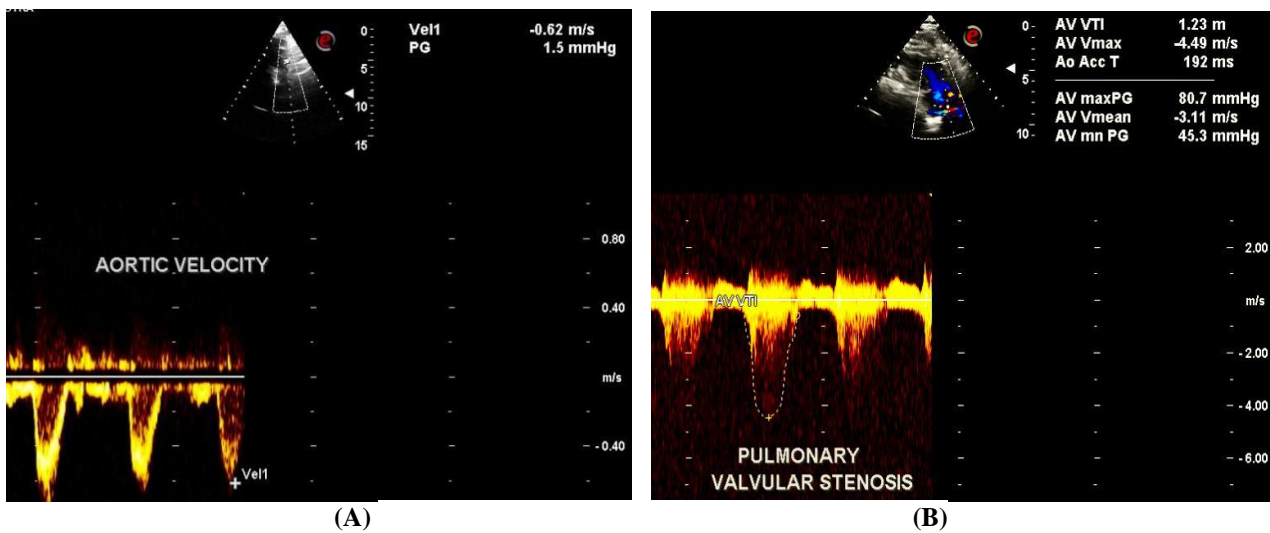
(A) Pulse Doppler flow across Aortic valve was normal; (B) Continuous flow across pulmonary valve identified severe pulmonary valvular stenosis with a peak and mean gradient of 80.5/45.3 mmHg.
